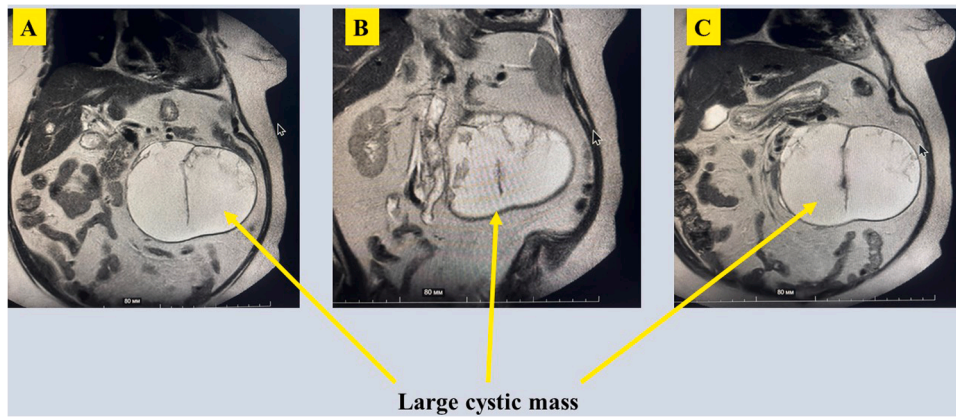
Coronal MRI View of the abdominal cyst.
